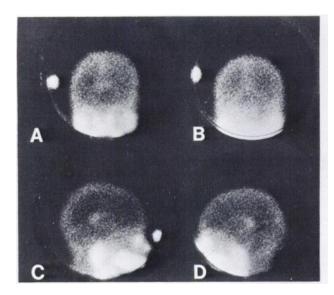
Pertechnetate brain scintigrams in normal patient. No perchlorate was given (patient comatose). Choroid-plexus uptake is seen in lateral ventricles. A = anterior; B = posterior; C = right lateral; D = left lateral. A subsequent pertechnetate brain study with perchlorate block showed no choroid activity.
